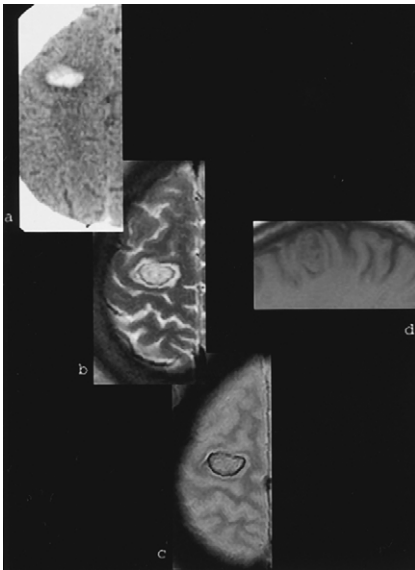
(a) Acute lobar hemorrhage in a patient with history of cocaine abuse. The only clue to the acute hematoma on MRI is the hypointense rim on the T2-weighted image as a result of deoxyhemoglobin formation at the periphery (b), which is much better depicted on the gradient-echo image (c). The lesion is barely perceptible on the T1-weighted image (d).
